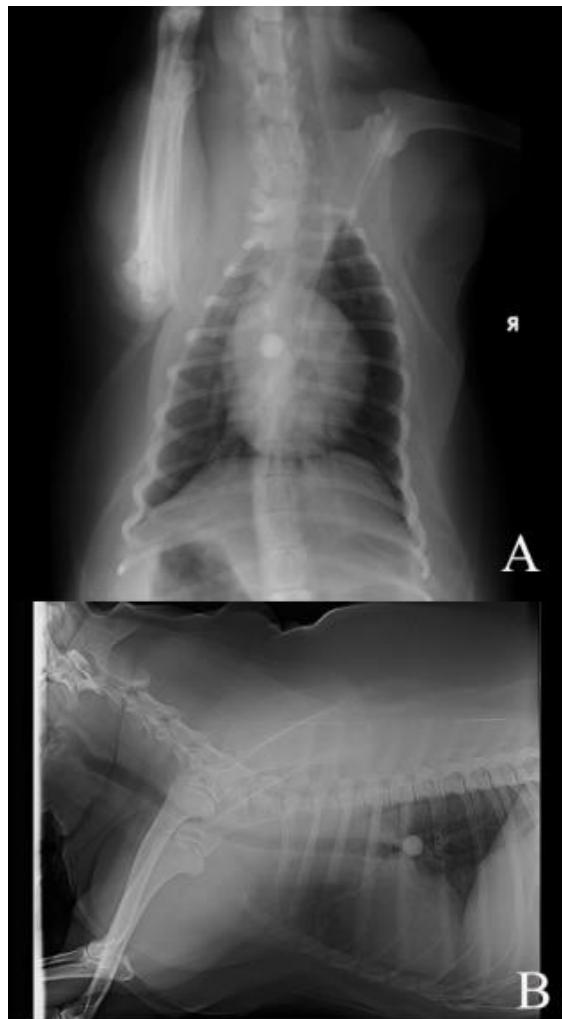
Dorso-ventral view thoracic radiograph (A) showed a circular radiopacity foreign body at the proximal left bronchi. Right Lateral view thoracic radiograph (B) showed a circular foreign body obstruction in the bronchus.
